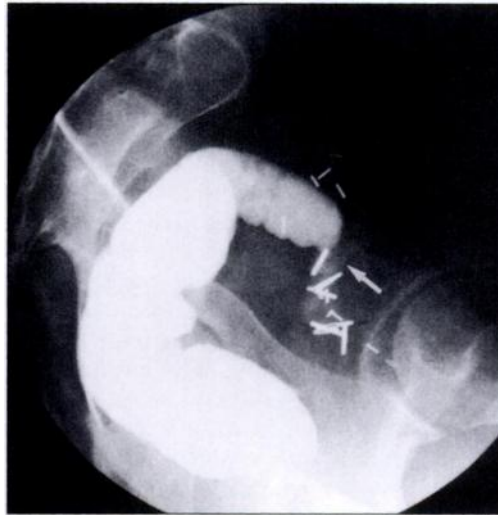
51-year-old woman with focal leak from Hartmann's pouch. Contrast-enhanced radiograph with water-soluble contrast medium shows extravasation from end of long transverse colonic stump into sealed-off 5-cm collection (arrows). Patient presented with clinical signs (e.g., fever and leukocytosis) of leak.
